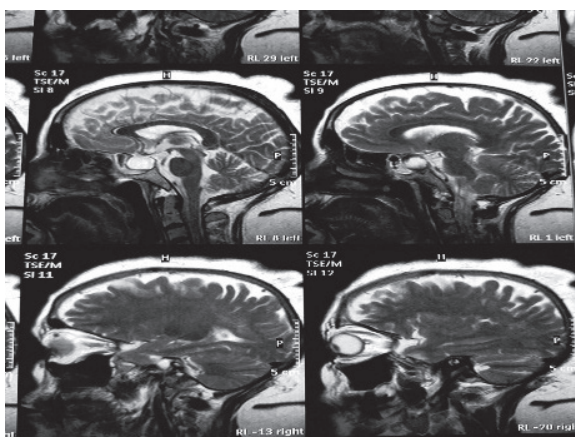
Showing CT scan bone and MRI brain T2WI and MRI brain with contrast showing defect in bone, CSF signal intensities with internal encephalocele
